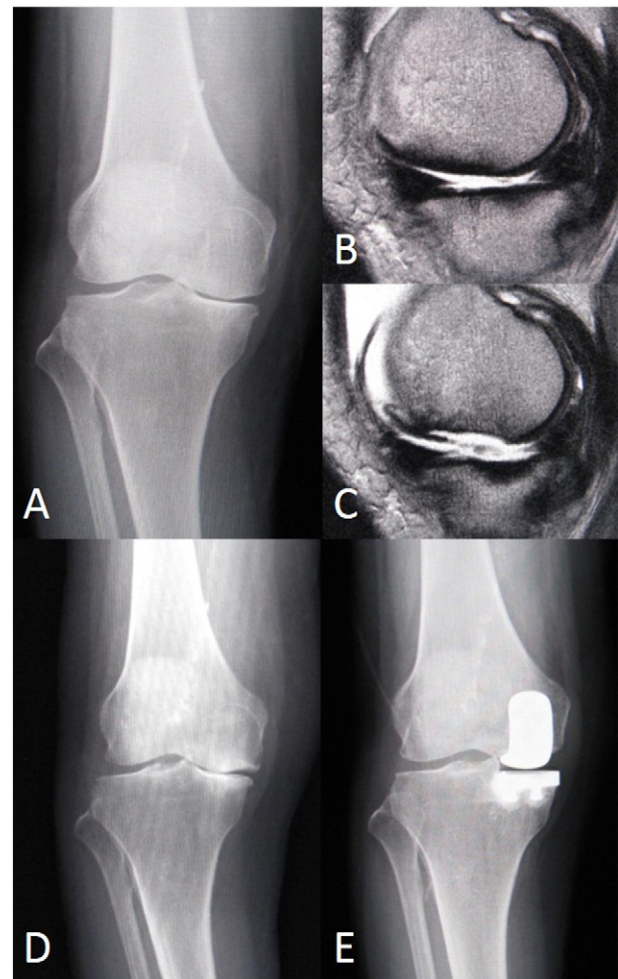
Sequential radiological and MRI findings of a 78-year-old female patient presenting poor prognosis. (A) A standing anteroposterior radiograph at initial examination indicates stage 1 change. The femorotibial angle is 185° and varus deformity is evident. (B) Sagittal T2-weighted MRI at initial presentation shows typical osteonecrosis lesion. (C) At two months, the osteonecrosis lesion advanced to stage 4 on T2-weighted MRI. Unicompartmental knee arthroplasty was indicated for this patient (D).
